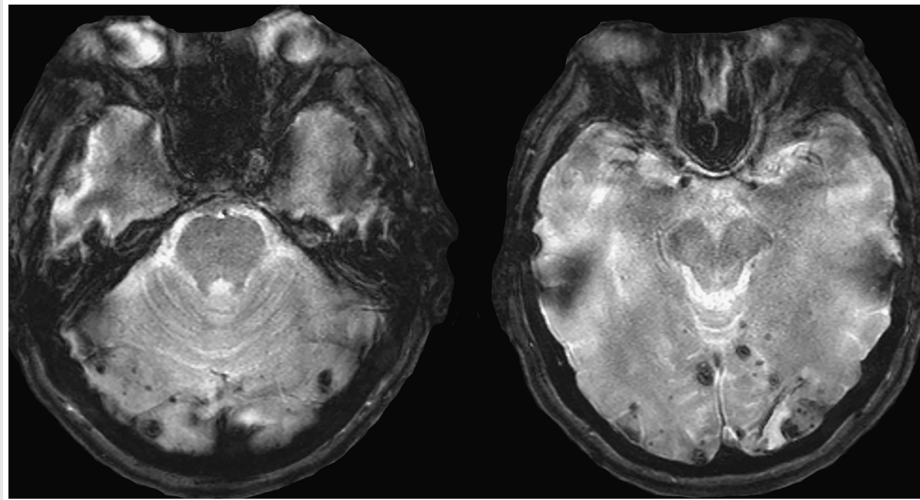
Cortico-subcortical microhemorrhages are often found on gradient echo MRI sequences and are suggestive of the presence of vascular amyloidosis.
